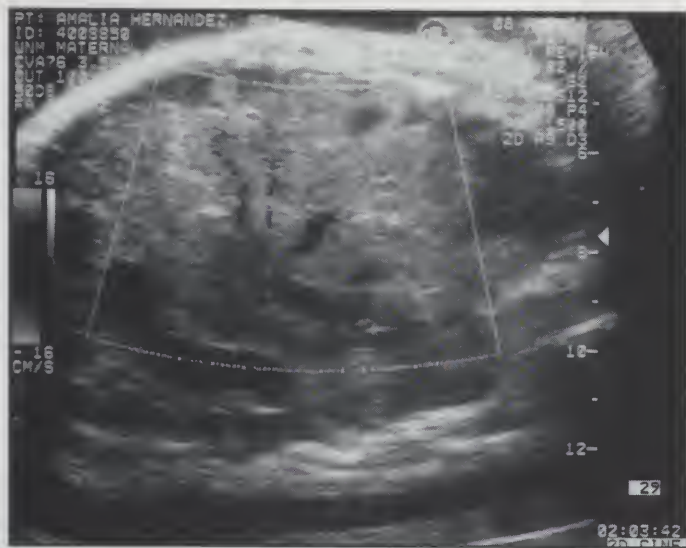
Sagittal view of the fetal chest. Note the presence of intrathoracic mass with evidence of color doppler representing flow from the umbilical to the hepatic vein.
